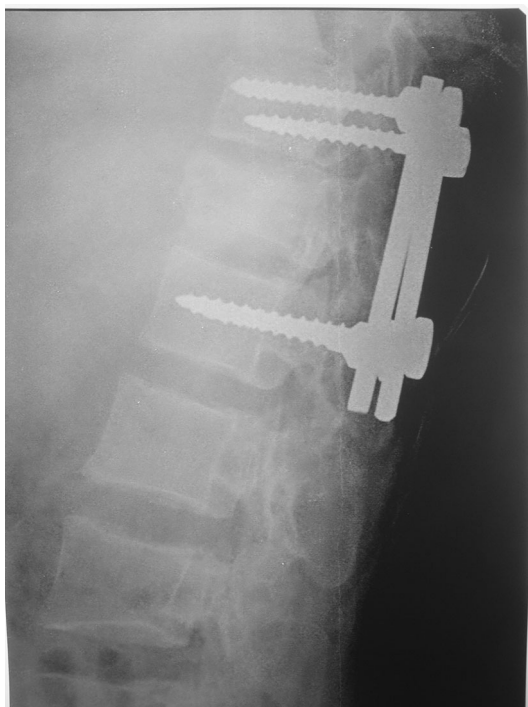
Postoperative radiograph: short-segment fixation done with pedicular screws
